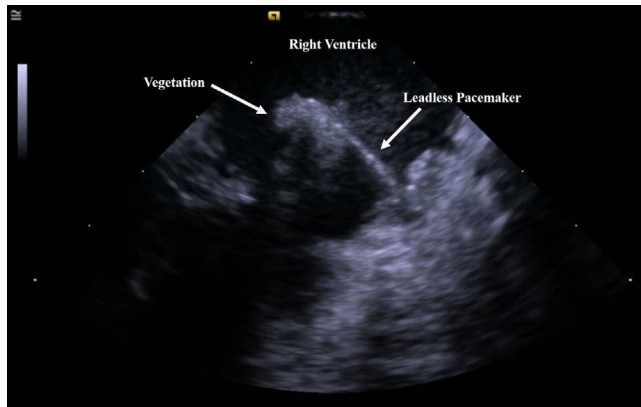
Intracardiac echocardiogram (ICE) image. The ICE catheter is positioned in the right ventricle, and it showed a large mobile vegetation attached to the pacemaker.
